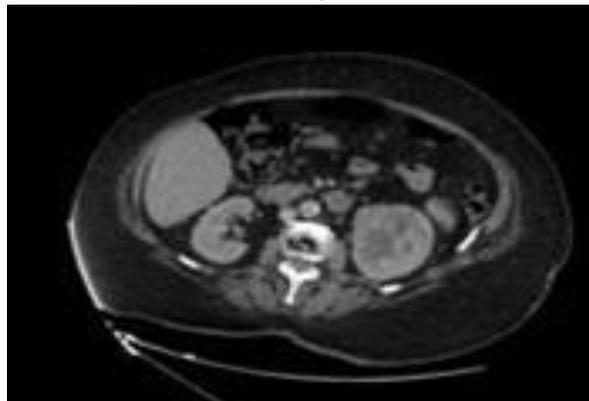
Left RCC on T-1 weighted MRI image.
